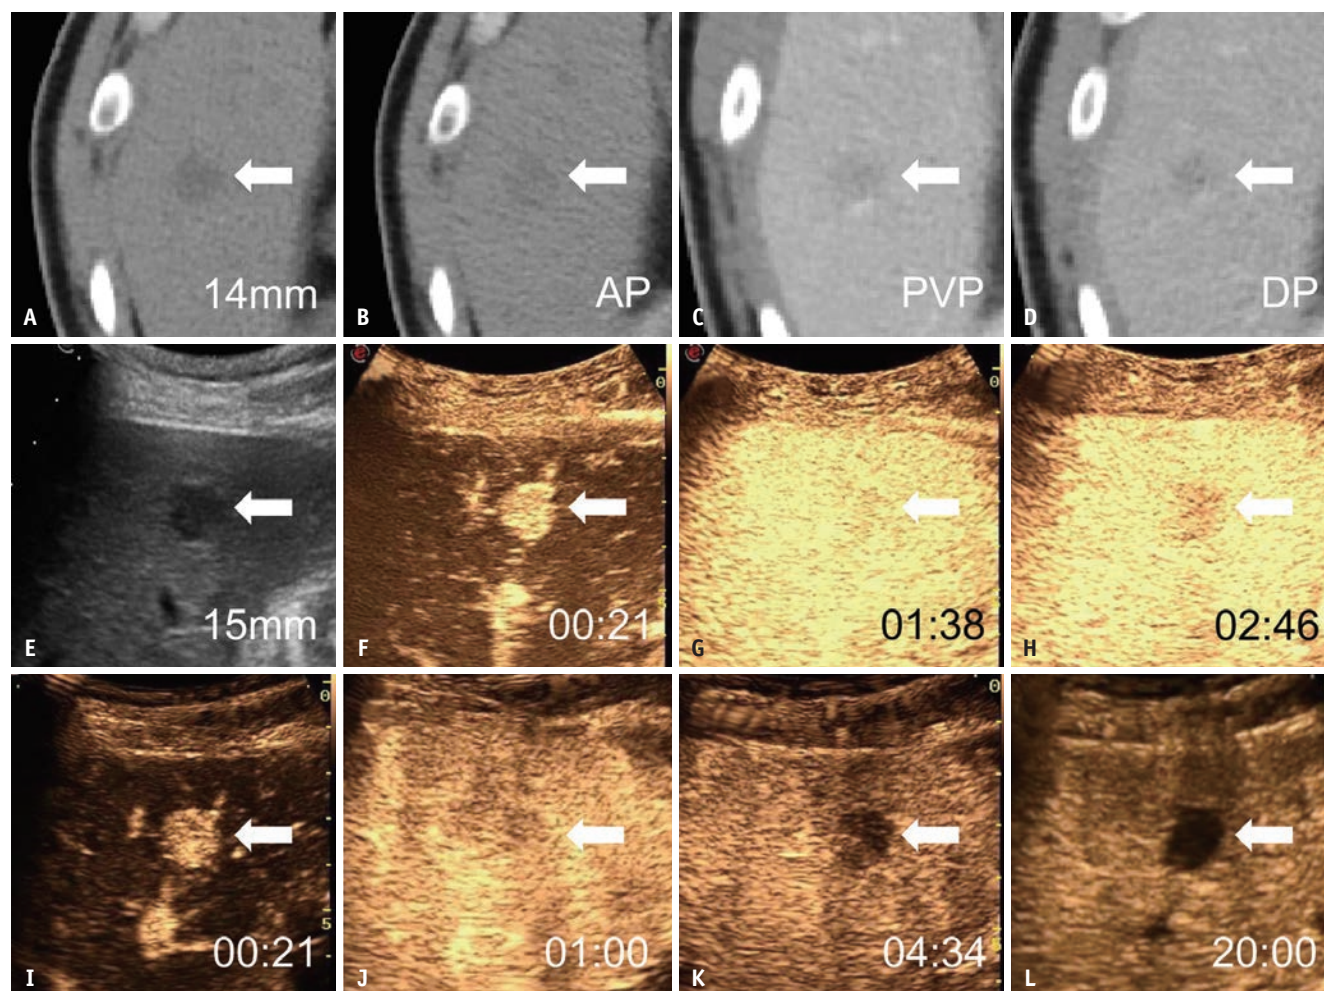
Images of a 39-year-old male at high risk of HCC due to chronic hepatitis B virus infection. A: On contrast-enhanced CT with iopromide, plain image shows a 14 mm hypodensity observation in segment VI (arrow). B: AP image showing the absence of non-rim APHE (arrow). C, D: PVP and DP images show non-peripheral washout (arrows). E: Grayscale US image showing a 15 mm hypoechoic observation in segment VI (arrow). F: On SHF-enhanced US, the AP image at 21 seconds shows non-rim APHE (arrow). G: Portal venous-phase image at 1:38 minutes shows no washout (arrow). H: Late-phase image at 2:46 minutes showing late and mild washout (arrow). I: On PFB-enhanced US, the AP image at 21 seconds shows non-rim APHE (arrow). J: PVP image at 1 minute showing no washout (arrow). K: Late-phase image at 4:34 minutes showing late and mild washout (arrow). L: Kupffer-phase image at 20 minutes shows a marked Kupffer defect (arrow). This observation was assigned as LR-3 by CT/MRI LI-RADS and LR-5 according to the following criteria: LI-RADS SHF, LI-RADS PFB, and modified PFB. The pathological diagnosis based on the needle biopsy was HCC. HCC = hepatocellular carcinoma, AP = arterial phase, APHE = arterial hyperenhancement, PVP = portal venous-phase, DP = delayed-phase, US = ultrasound, SHF = sulfur hexafluoride, PFB = perfluorobutane, LI-RADS = Liver Imaging Reporting and Data System
